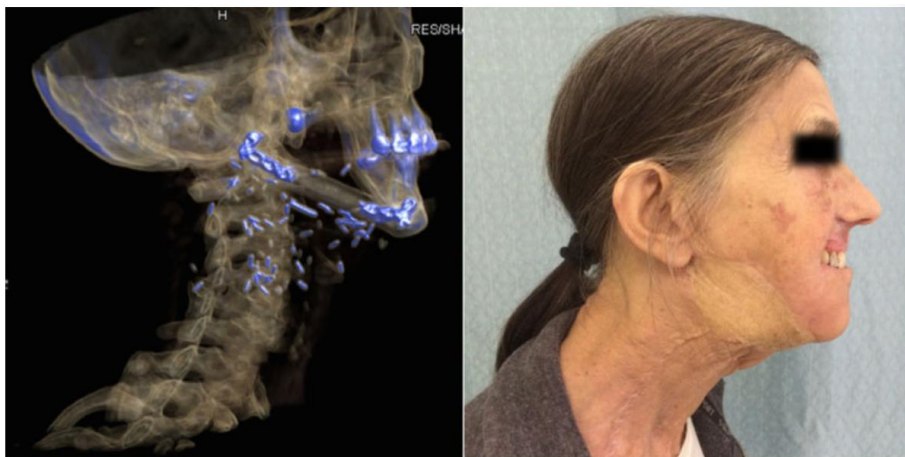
Seven-month post-operative three-dimensional computed tomography and clinical photograph.
